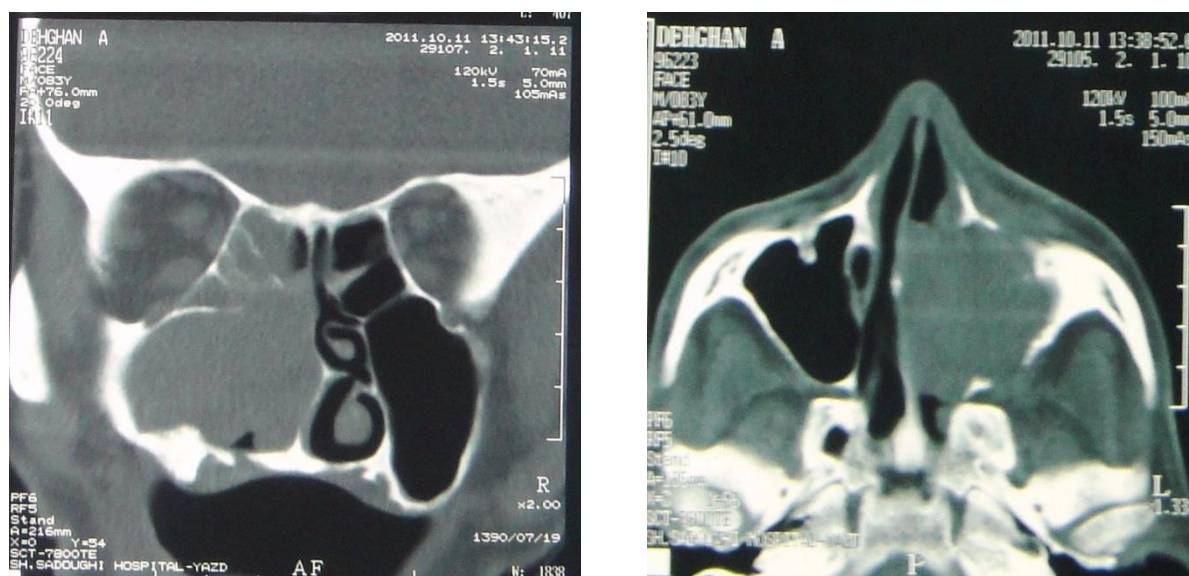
A, Coronal and B, Axial computerized tomographs (CT)
